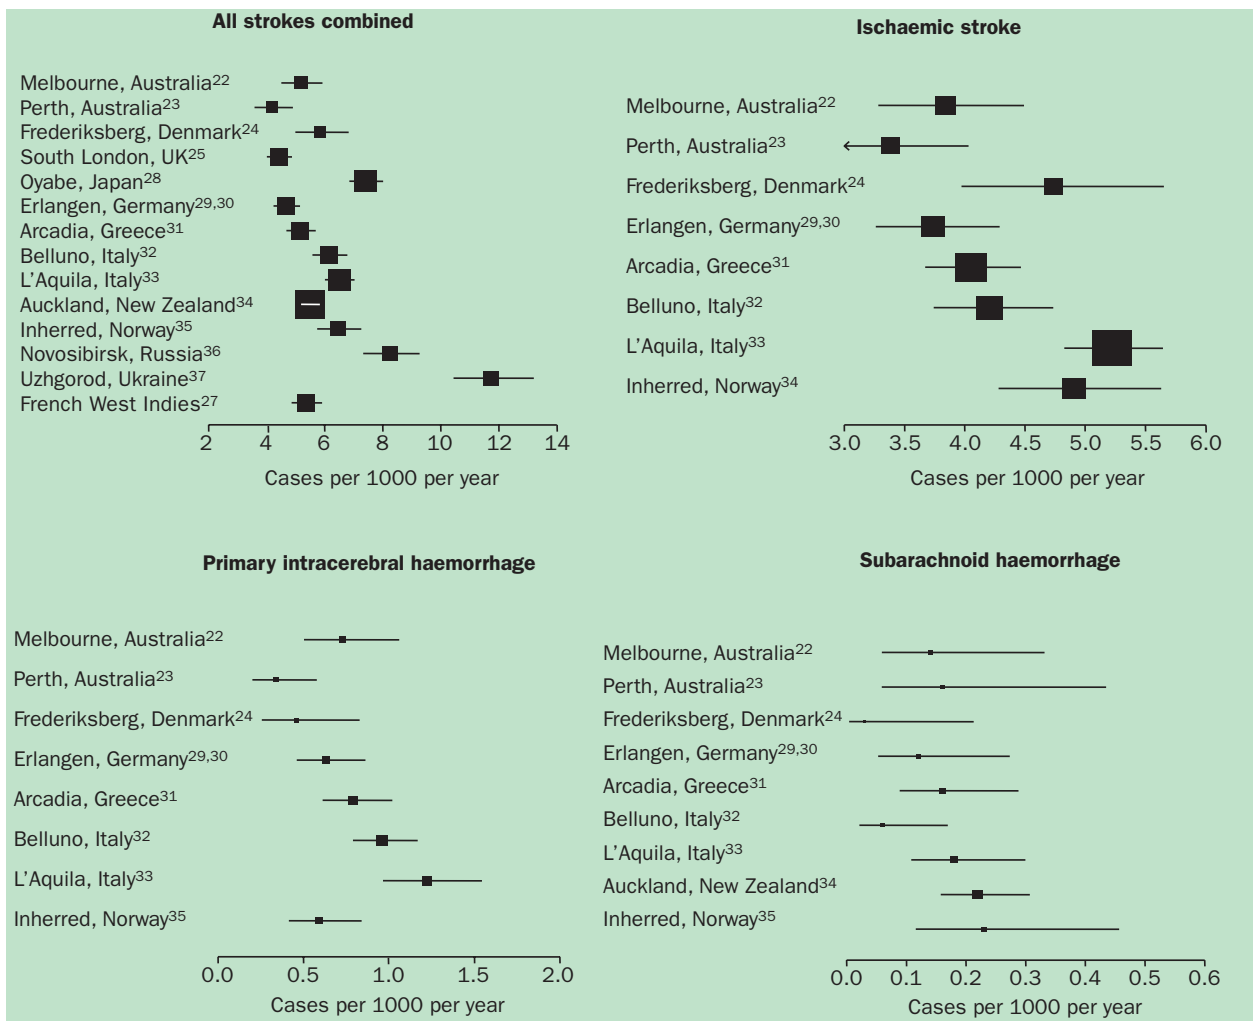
Age-standardised annual incidence per 1000 population of all strokes combined in people aged  $\geq 55$  years. Only studies in which a CT, MRI, or autopsy was done in more than 70% of cases were included in the analyses of stroke types. All stroke-type analyses were based on cases classified by CT, MRI, or autopsy findings for ischaemic stroke and primary intracerebral haemorrhage, or CSF examination and/or cerebral angiography for subarachnoid haemorrhage. The error bars are 95% CIs. Box size is proportional to the number of events contributing to the analysis in each graph.
